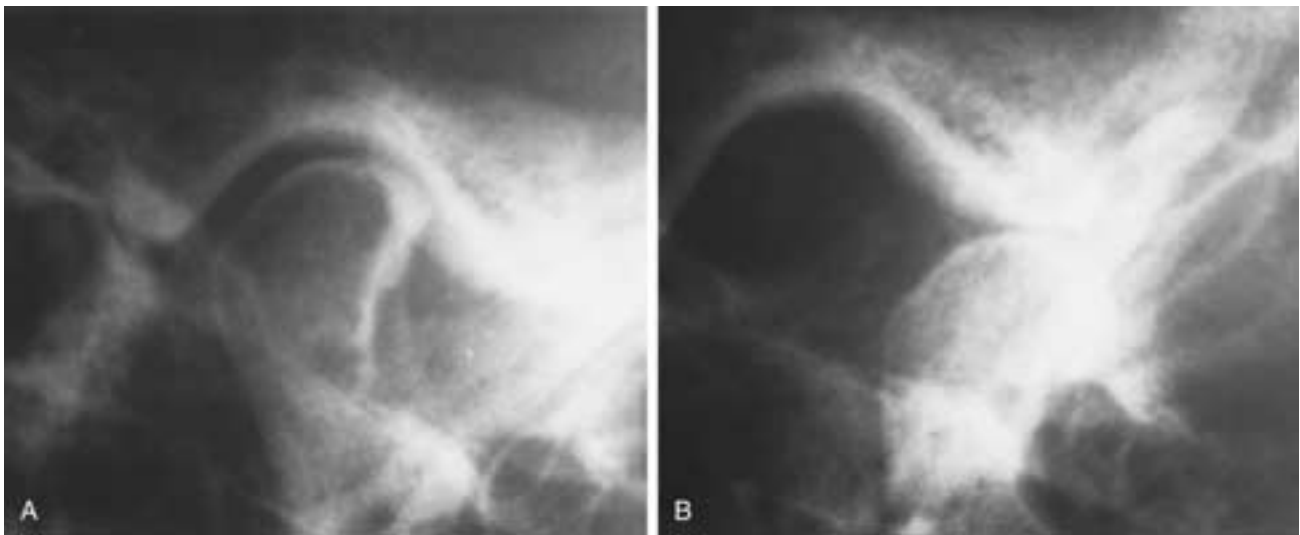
Transcranial plain film in the closed-mouth (A) and open-mouth (B) positions 29 years after diskectomy. The osseous structures are relatively normal, with only a decreased joint space. The outline of the condyle and temporal joint components is smooth, without evidence of degenerative joint disease.
